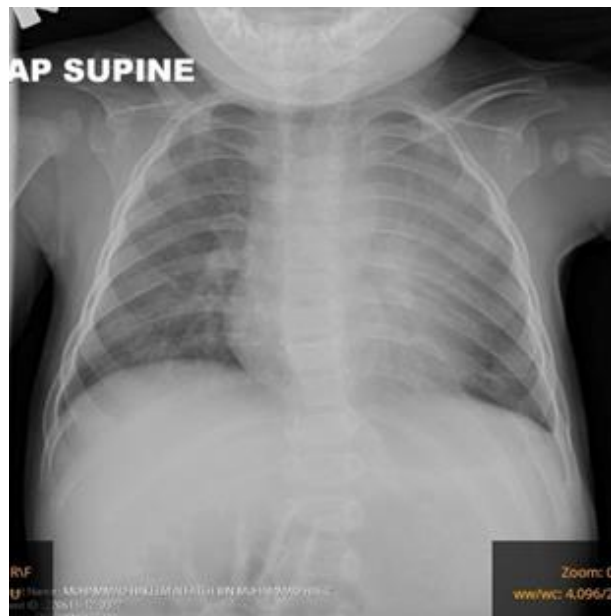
chest radiograph during follow-up at 8 months old. Both lungs well expanded. Some opacity over left middle zone is seen, which may be caused by pleural thickening post pleurodesis.
